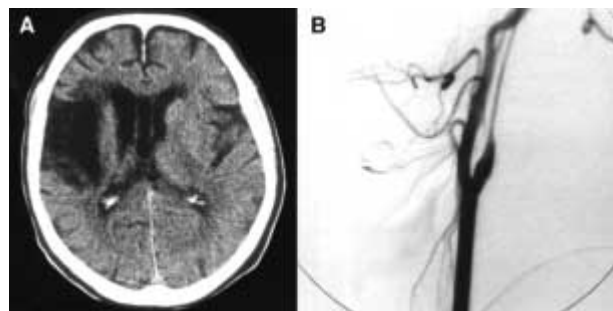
A. CT scan of the brain showing the right peri-insular and deep infarct in the middle cerebral artery territory.
